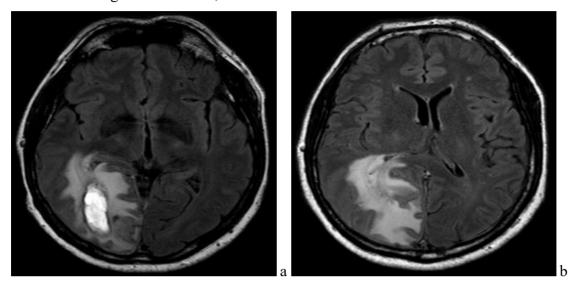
MRI of the Brain. Axial plane (a,b,c,d), Sagittal plane (e)
